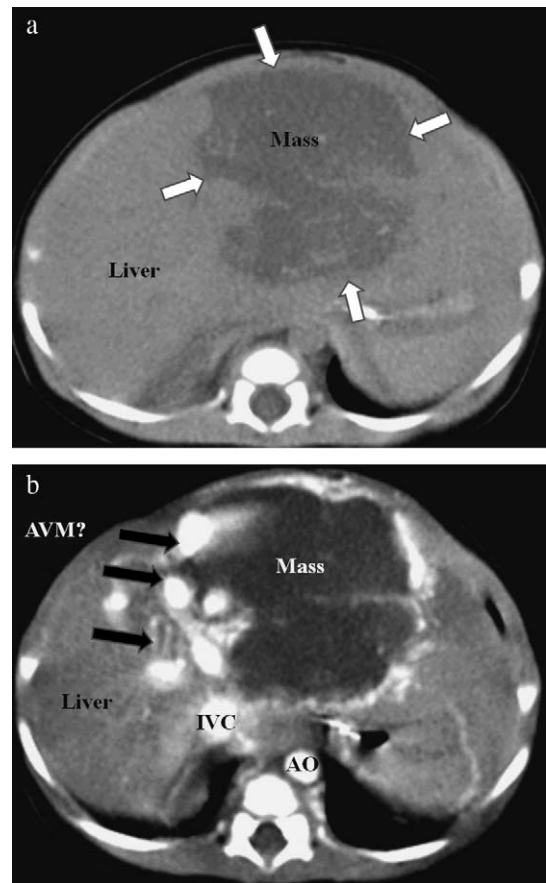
Hepatic hemangioendothelioma with arteriovenous malformation? (a,b) Plain and contrast-enhanced computed tomography indicated a hypervascular tumor with neovascular formation. This patient was treated with the combination of steroid, radiation, and interventional radiology with a favorable outcome.
